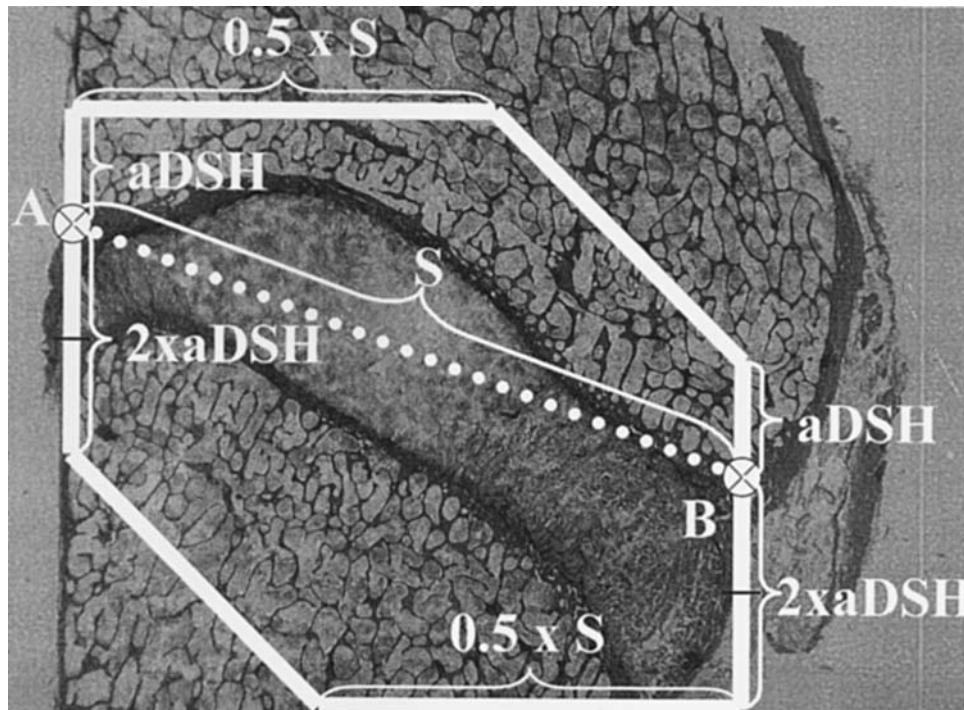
Region of interest for histomorphometric evaluation. The ROI for histomorphometric evaluation was determined using the points A (posterior edge of the C-3 endplate) and B (anterior edge of the C-3 endplate) and the preoperative average DSH (aDSH) evaluated on lateral x-ray films of the C3-4 motion segment. The distance between A and B was defined as the sagittal diameter distance (S). From points A and B a line was drawn with a distance of one aDSH in cranial and two aDSH (2×aDSH) in caudal direction. From the resulting upper and lower endpoints, an additional horizontal line was drawn with a distance of half S ($0.5 \times S$). Interconnecting the resultant endpoints leads to a hexagonal structure representing the complete ROI for histomorphometric evaluation.
